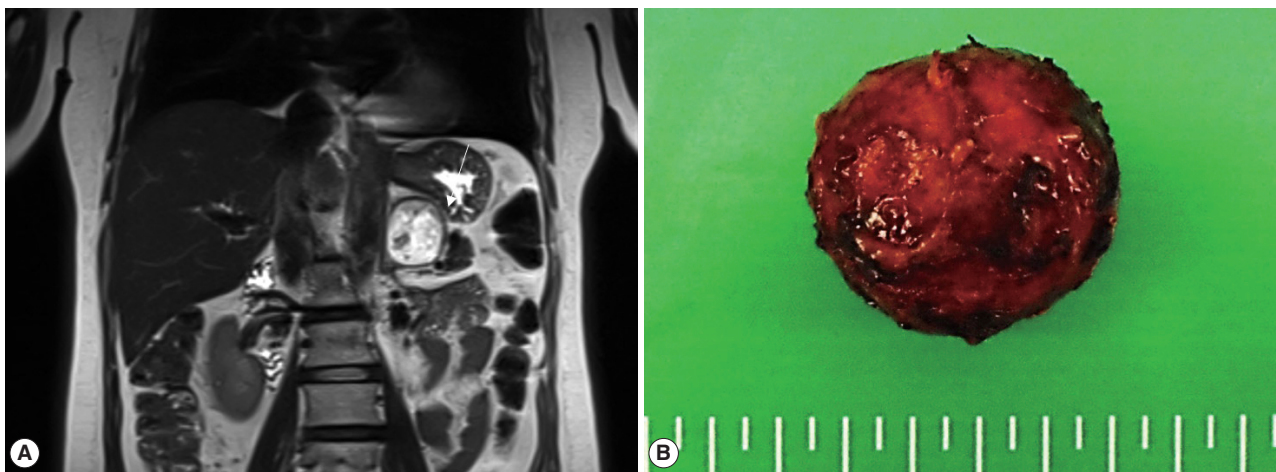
(A) Magnetic resonance imaging reveals a 4.2 × 3.6 × 4.2 cm mass in the left adrenal gland. (B) Gross examination shows an encapsulated nodular mass.
